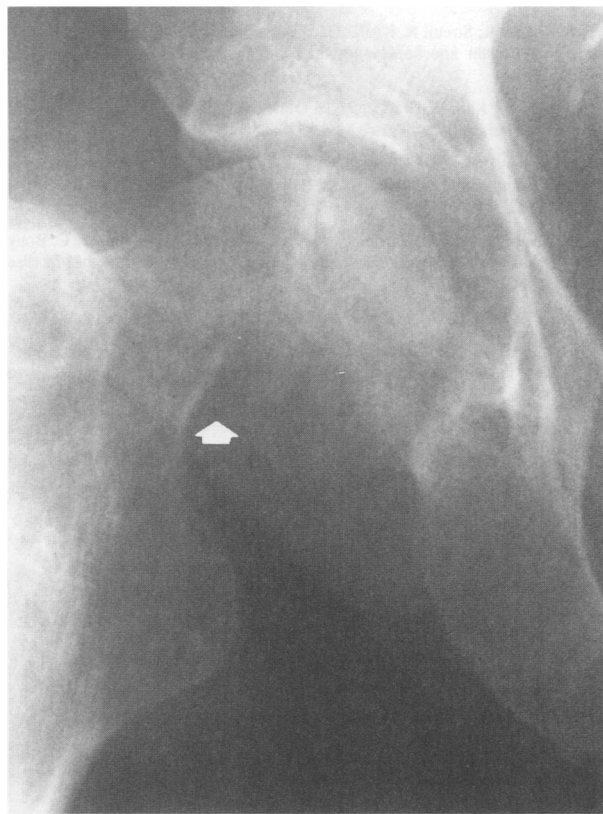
This anteroposterior radiograph of the right proximal femur demonstrates a shortening and angulation (white arrow) of the neck of the femur with overlap consistent with a femoral neck fracture.
